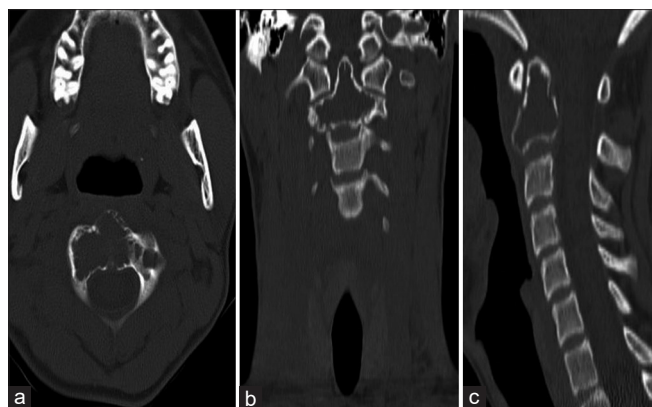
Preoperation cervical spine Computed tomography scan examination, showing an expansile osteolytic lesion with cortical insufflation of C2 vertebral body, involving odontoid process. Axial, coronal, and sagittal views of C2 vertebra from left to right, respectively. CT: Computerized tomography. axial (a), coronal (b), sagittal (c)
